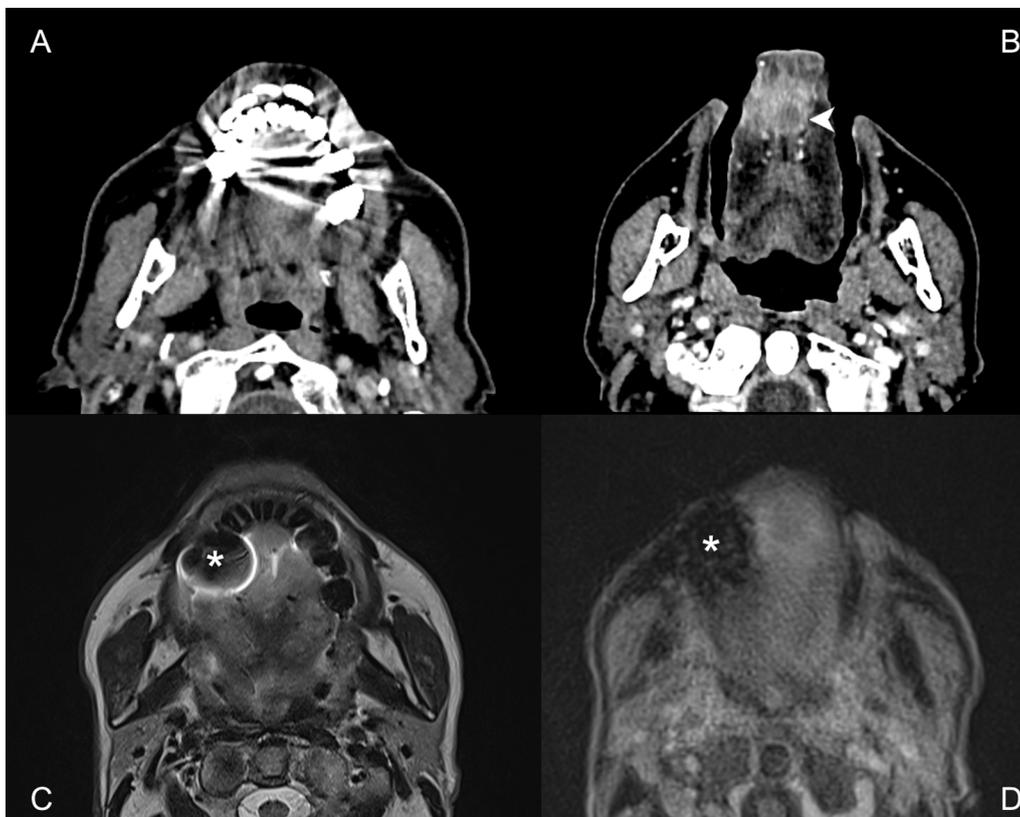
T4a staged Tongue carcinoma: case of better conspicuity of the tumor with a CTmote compared to CTconv and MRI due to artifacts. CT with injection in axial section centered on oral cavity, conventional closed mouth (A), in MOTE maneuver (B). MRI in T2 (C) and T1 weighted axial section with gadolinium injection and fat saturation (D). A 58-year-old man, tobacco and alcohol consumer, with squamous cell carcinoma cT4aN2bM0 (pT4a) of the mobile tongue, found during a glosso-dynia assessment with dysphagia. In image A, important dental metal artifacts mask the tongue and prevent the tumor from being seen. In image B, the mouth opening removes the dental amalgams from the tumor and removes the metal artifacts at this level. A medial nodular contrast (arrow head) of the mobile tongue is then visualized. The invasion of the genio-glossus muscle is better visualized on the sagittal sections. The MRI sections (C, D) show an image distortion related to dental amalgam (*), barely distinguishable to the nodular contrast of the T1 images with gadolinium injection (D). The T1 sequence with injection of gadolinium (D) is also artefacted by the patient's movements.
